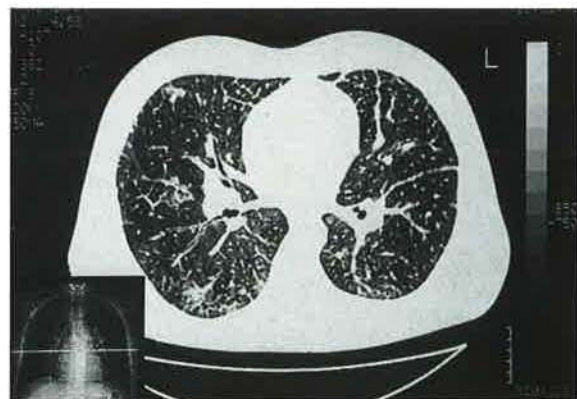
A slice of the computed tomographic (CT) scan shows thickened interlobular septae, mainly subpleurally, but also extending centrally. The left main fissure also appears thickened.
